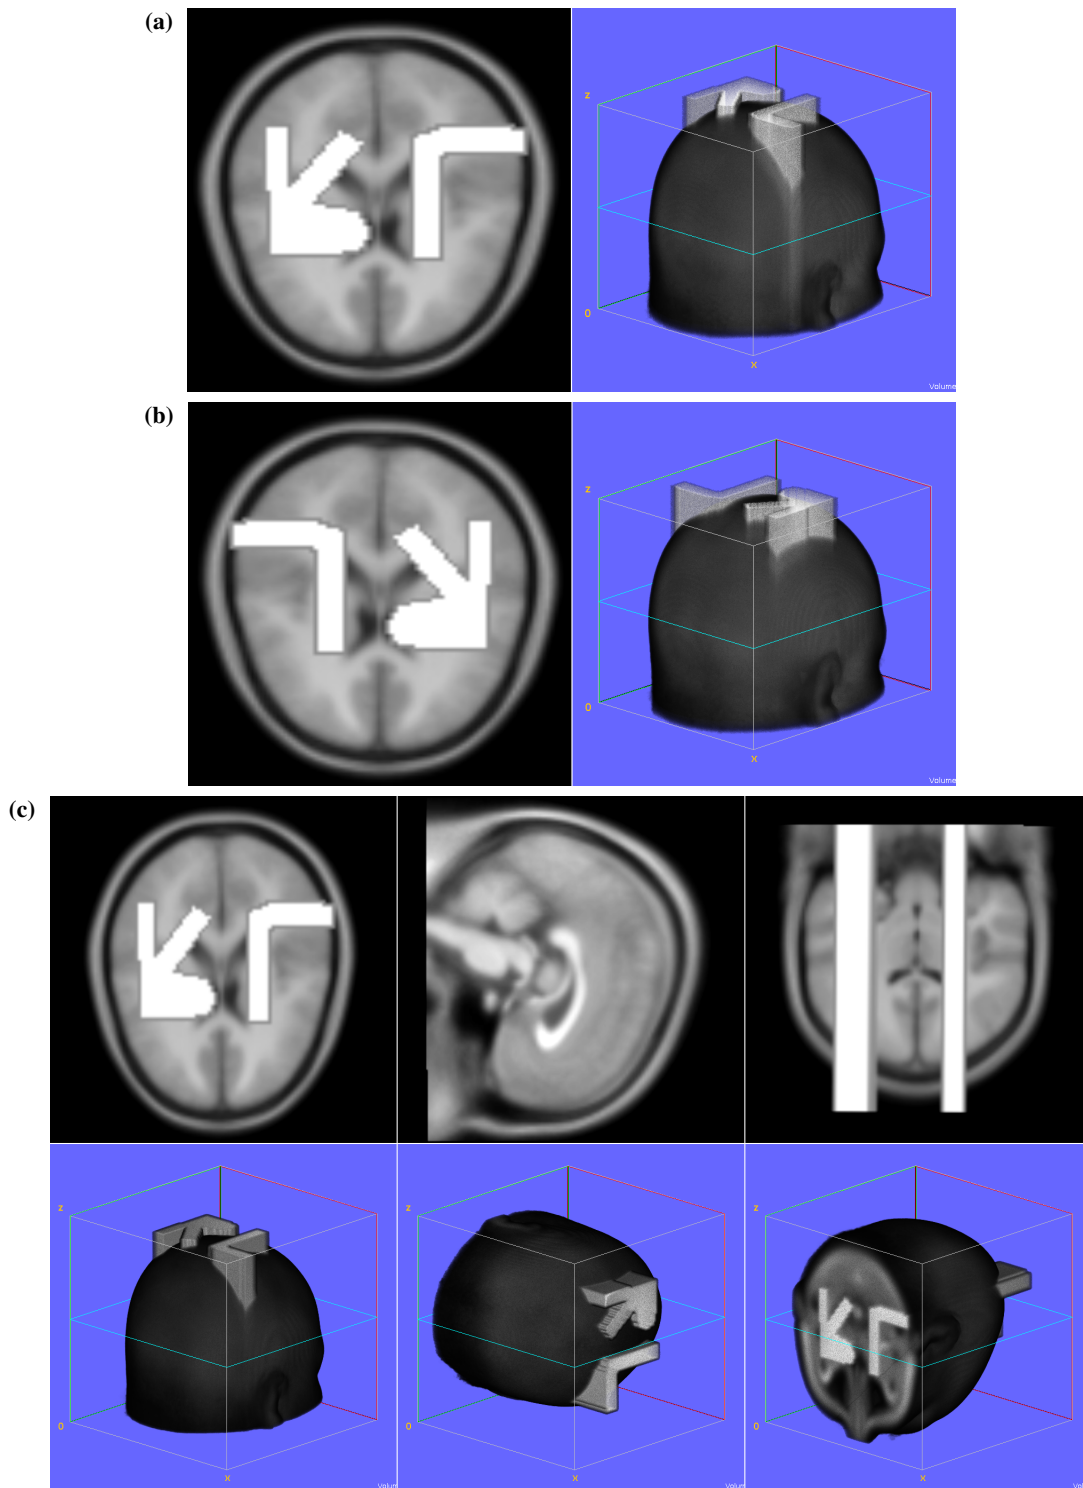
The relative position of left (labelled as an upside down 'L') and right (labelled as an upside down 'R') brain hemispheres in MR images is kept correct after rotation by the script. (a) A radiological view of brain 'avg152T1_LR_nifti.nii.gz' shown in both 2D and 3D images before being processed by the script. (b) A neurological view of brain 'avg152T1_RL_nifti.nii.gz' before being processed by the script. (c) The brain in radiological convention after being processed by the R script in three orthogonal positions.
